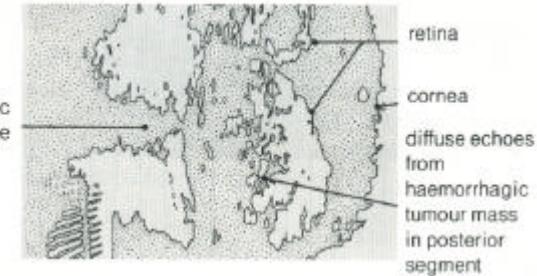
This patient had a long-standing blind right eye and presented with recent onset of pain, conjunctival oedema, and haemorrhage into the anterior chamber. The ultrasound scan of this patient shows posterior segment echoes which are suggestive of a tumour mass.
